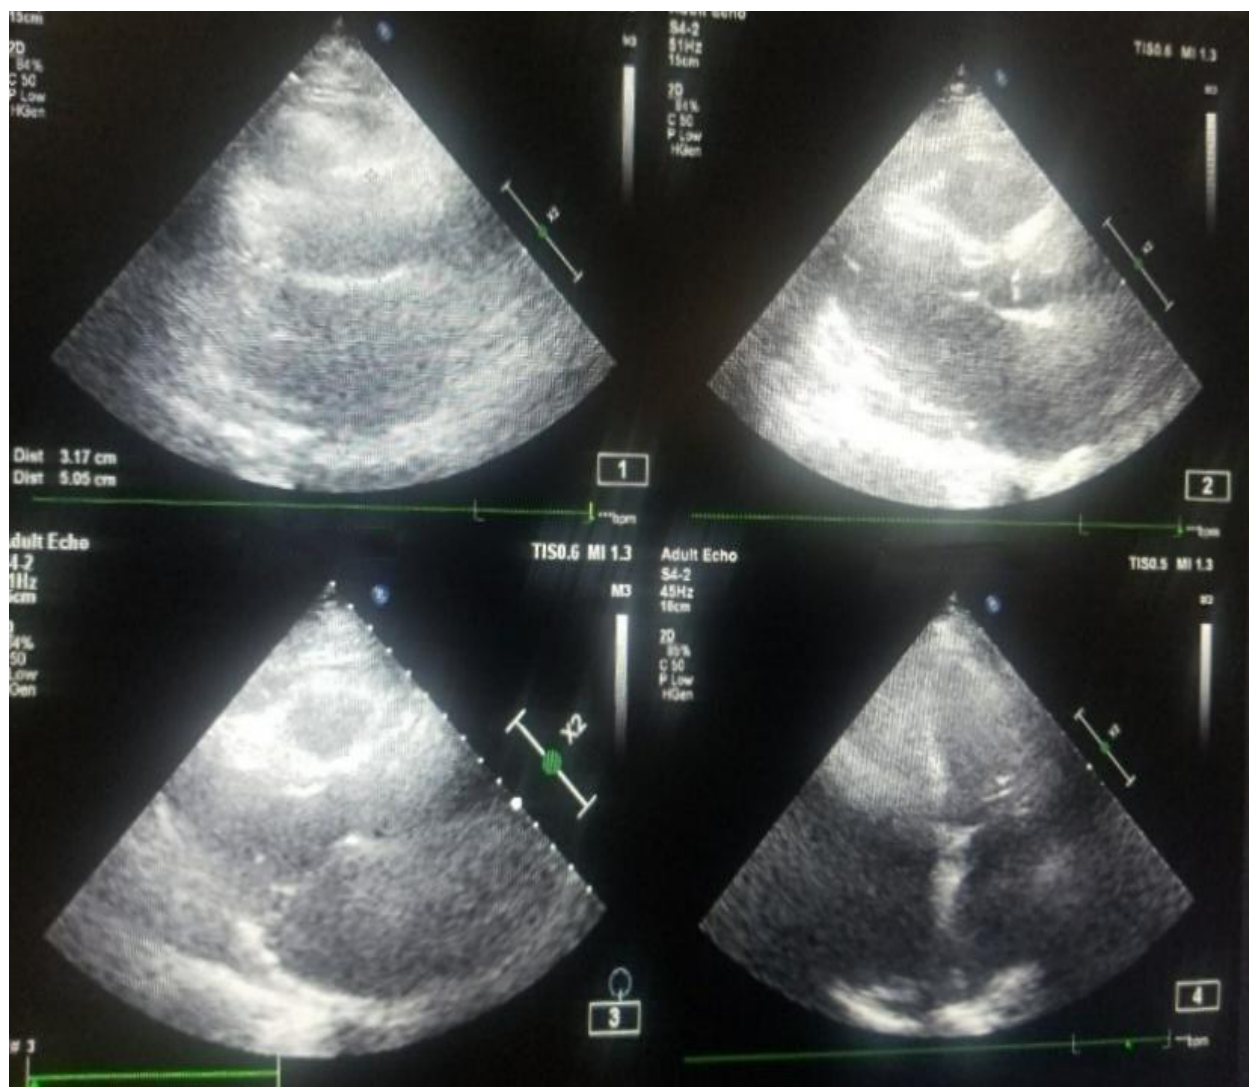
Post operative follow up Echocardiography
